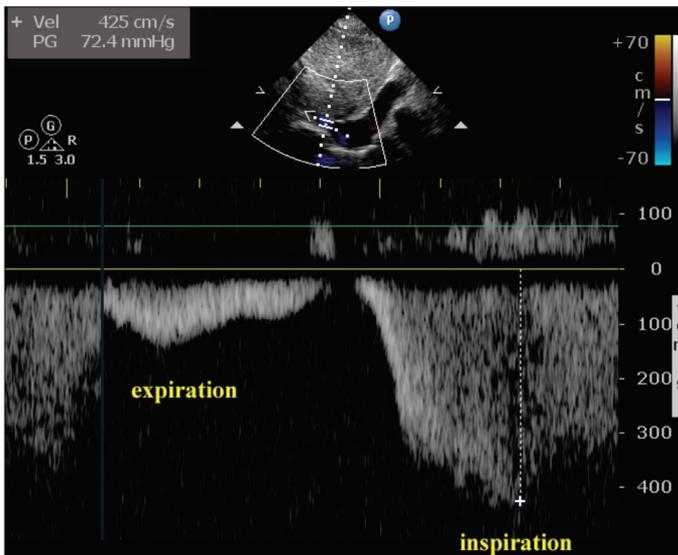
Doppler echocardiography view of dynamic obstruction at deep inspiration with peak pressure gradient of 72 mm Hg gradient and remarkable reduction of pressure gradient at expiration
